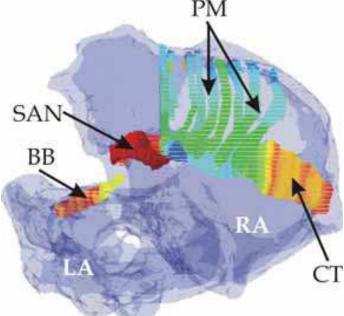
3D anatomical model of the human female atria showing internal structure and conduction pathways (figure adapted from our previous study (Zhang, Garratt et al. 2009)). Atrial tissue in the left (LA) and right (RA) atria is homogeneous (translucent blue). The sino-atrial node (SAN) is the pacemaker wherefrom cardiac electrical excitations originate. The main atrial conduction pathways, *i.e.* pectinate muscles (PM), cristae terminalis (CT) and the Bachman's bundles (BB), are the tissue types which possess electrical and structural heterogeneity and contribute to a small proportion of total atrial mass.
